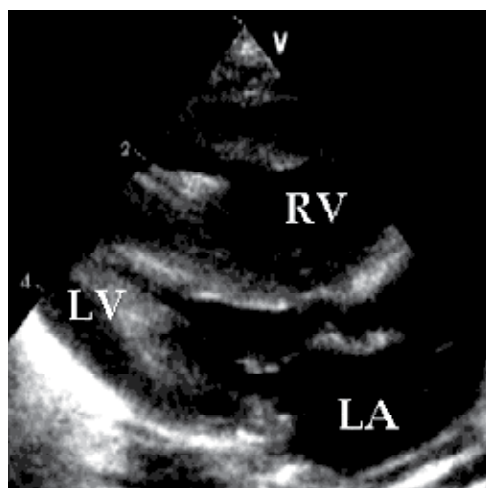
Echocardiographic parasternal long axis view of borderline left heart in a neonate with aortic stenosis, left ventricular hypertrophy, and endocardial fibroelastosis.
